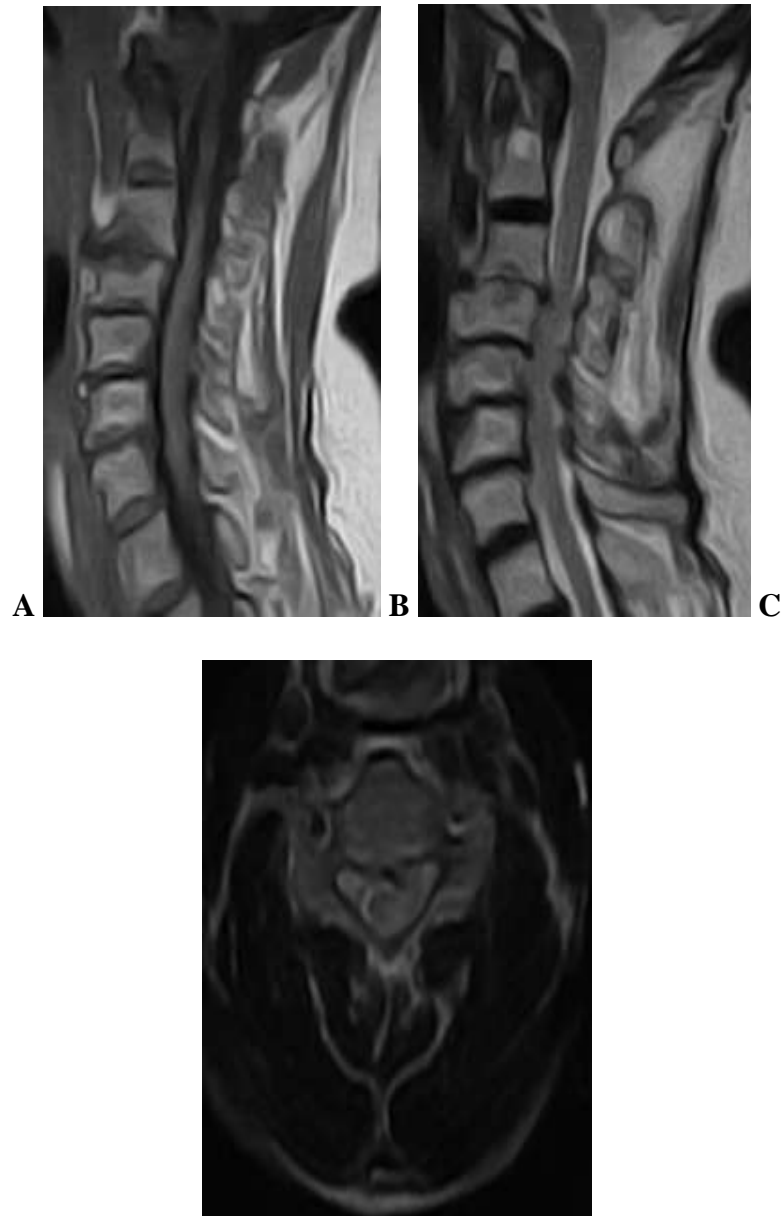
T2WI cervical spine MRI of a 49-year-old man who presented with 9-months history of numbness of the right upper limb and axial neck pain. A. Sagittal plane revealed multilevel intervertebral disc desiccation and maximum spinal cord compression at C6/7 caused by posterior disc bulge and LFH at C6/7. There was also subtle posterior disc bulges at C5/6 and C7/T1 and LFH at C5/6. B. Axial plane at C7/T1 level shows posterior disc bulge and LFH causing vertebral canal stenosis and cord compression.
